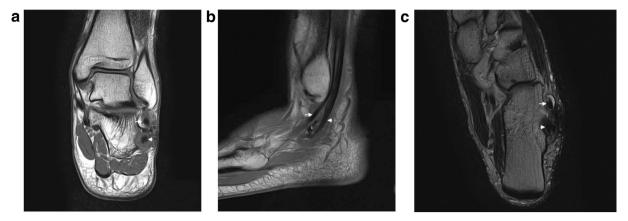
Coronal (A) and sagittal (B) T1-weighted and axial T2-weighted (C) magnetic resonance images: the peroneus brevis tendon (arrow) and the peroneus longus tendon (arrowhead) are running over and below the peroneal tubercle (§), the repaired inferior peroneal retinaculum (<) is visible.
